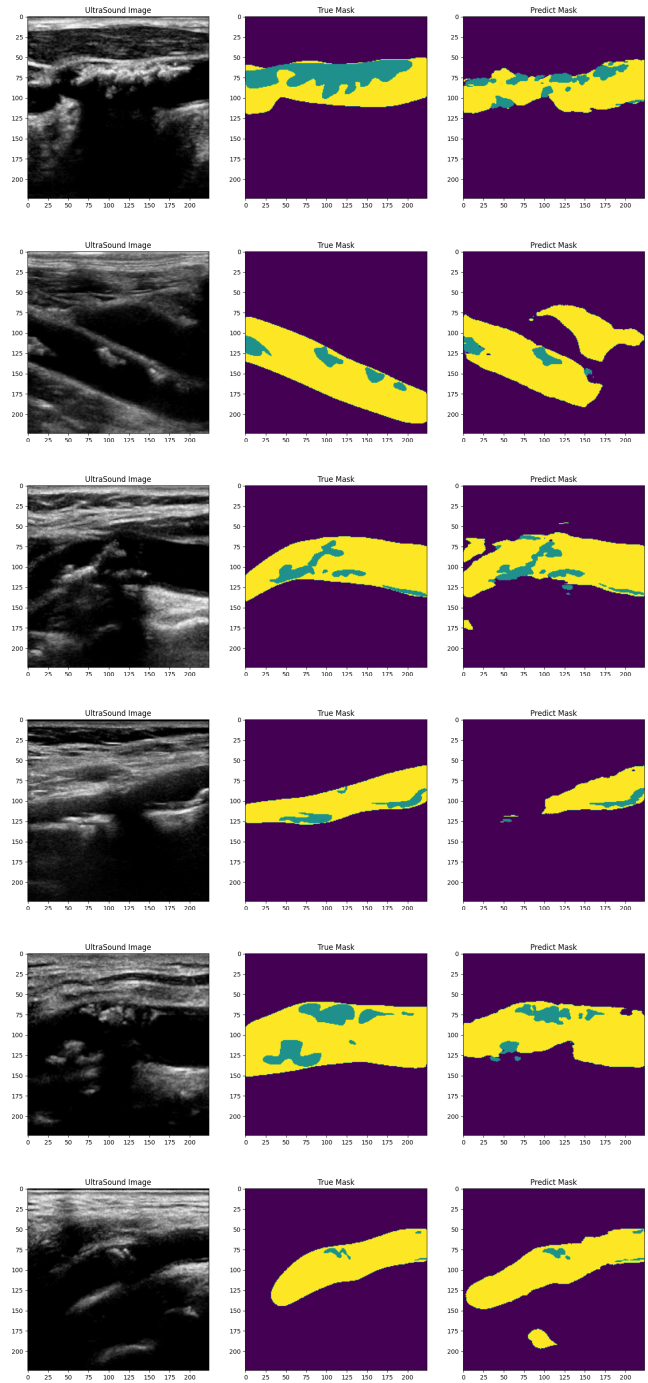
Examples of ultrasound images and their true and predicted segmentations. In yellow is the vessel and green is the plaque. These are handpicked images where our model performs relatively poorly compared to images in Figure 5.
